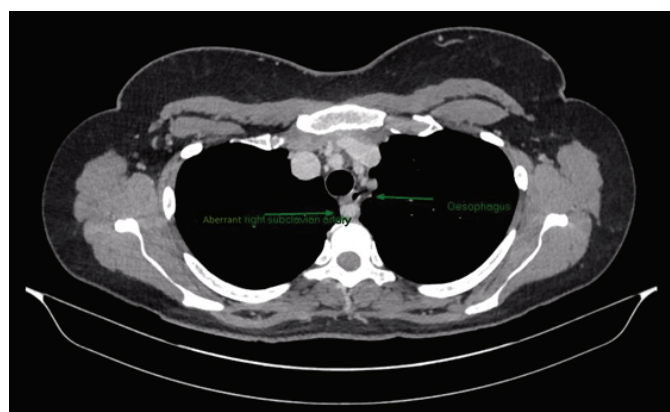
An axial non-contrast computed tomography scan of the patient's thorax. The compressed oesophagus and aberrant right subclavian artery are highlighted with green arrows.
